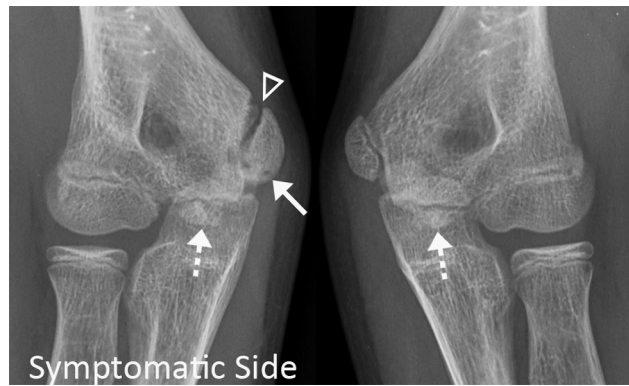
Primary stress injury (PSI) involving the medial epicondylar apophysis. Oblique radiographs from the symptomatic (left image) and asymptomatic comparison elbows (right image) show stereotypical findings of overuse with asymmetric physeal widening (triangle), sclerosis, fragmentation, and overgrowth of the symptomatic medial epicondyle (arrow). Note the normal irregular and sclerotic normal appearance of the trochlear ossifications bilaterally (dashed arrows).
